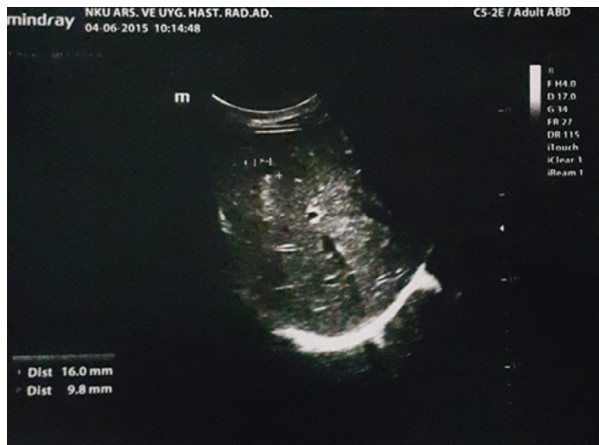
Ultrasonography of the liver showing small echogenic foci.
